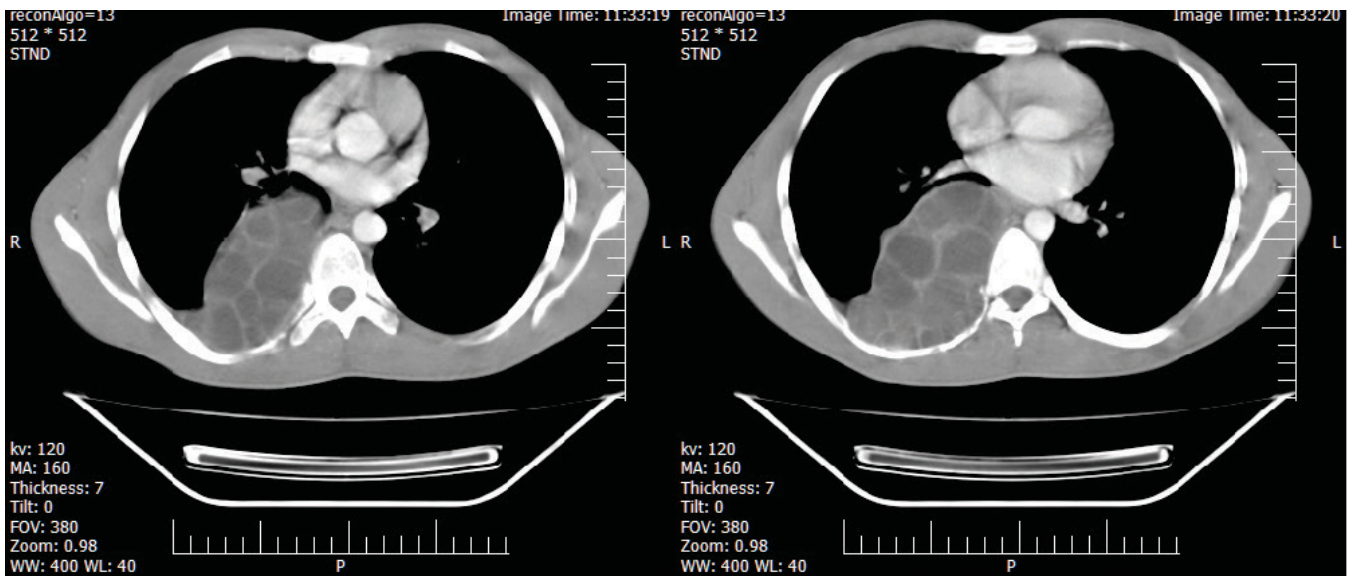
CT scan of chest with IV contrast shows a cystic and solid mass of posterior mediastinum
